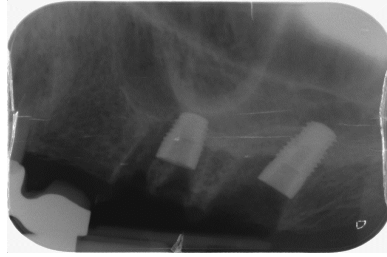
Intraoral X-rays showing implant placement.*
